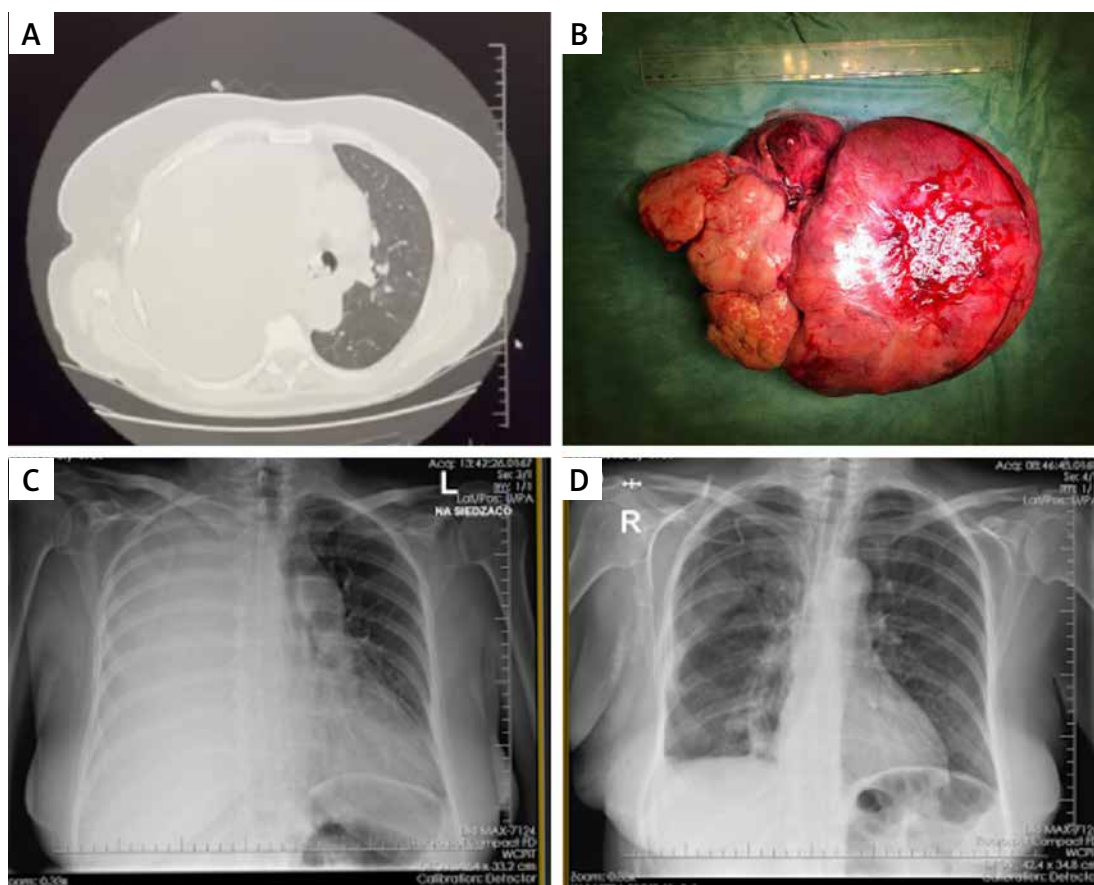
A – Mass in the right hemithorax with complete lung atelectasis and mediastinal shift to the left. B – A 7 kg tumor with 32.0 × 24.0 × 11.5 cm dimensions. An X-ray performed before (C) and after (D) the surgery
